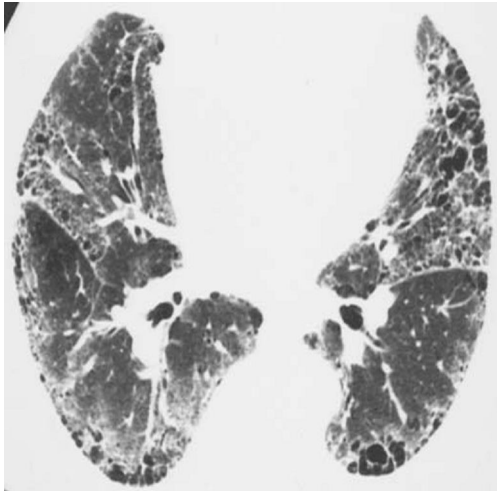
Computed tomography image through the lower lungs in a patient with IPF showing bilateral basilar/subpleural reticular infiltrates with predominantly subpleural honeycombing.
